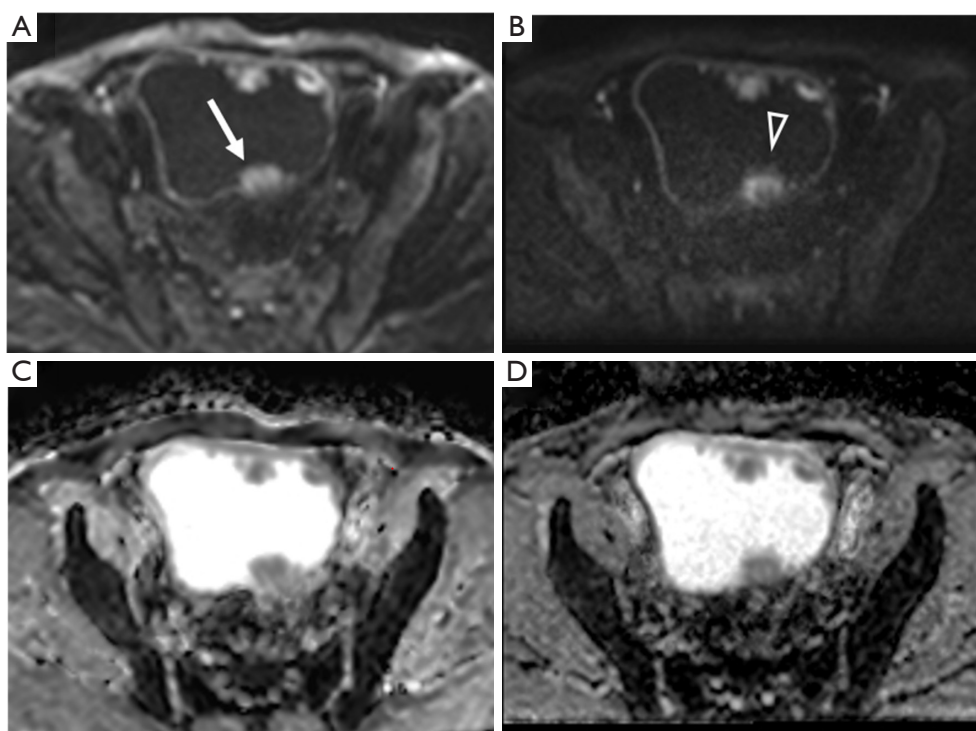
Image quality assessment between iShim and SS-EPI DWI in patients with bladder cancer. (A) iShim DWI showing a lesion (white arrow) in the left posterior wall of the bladder with a clear edge. (B) SS-EPI DWI showing an artifact (triangle) in front of the lesion. (C) iShim ADC showing a uniform urine signal. (D) SS-EPI ADC showing an uneven urine signal. iShim, integrated slice-specific dynamic shimming; SS-EPI, single-shot echo-planar imaging; DWI, diffusion-weighted imaging; ADC, apparent diffusion coefficient.
